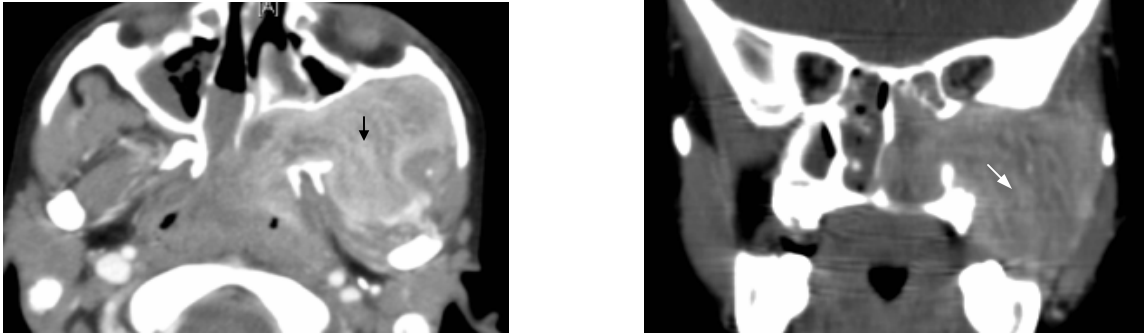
Coronal CT scan shows a mass filling left nasal cavity, nasopharynx, pterygopalatine fossa and infratemporal fossa (*black arrow*).b. Axial CT scan filling left infratemporal fossa(*white arrow*).
